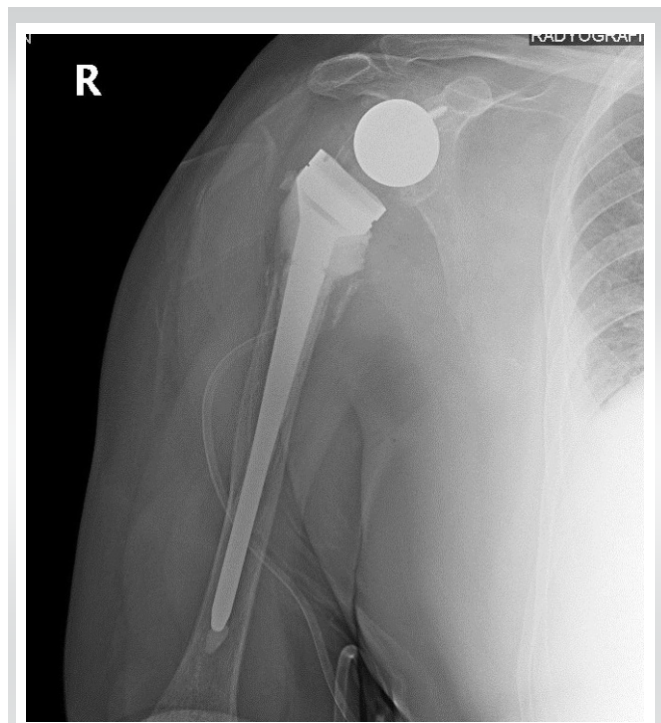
Post-operative radiograph of the revised reverse total shoulder arthroplasty with cemented long humeral stem.
